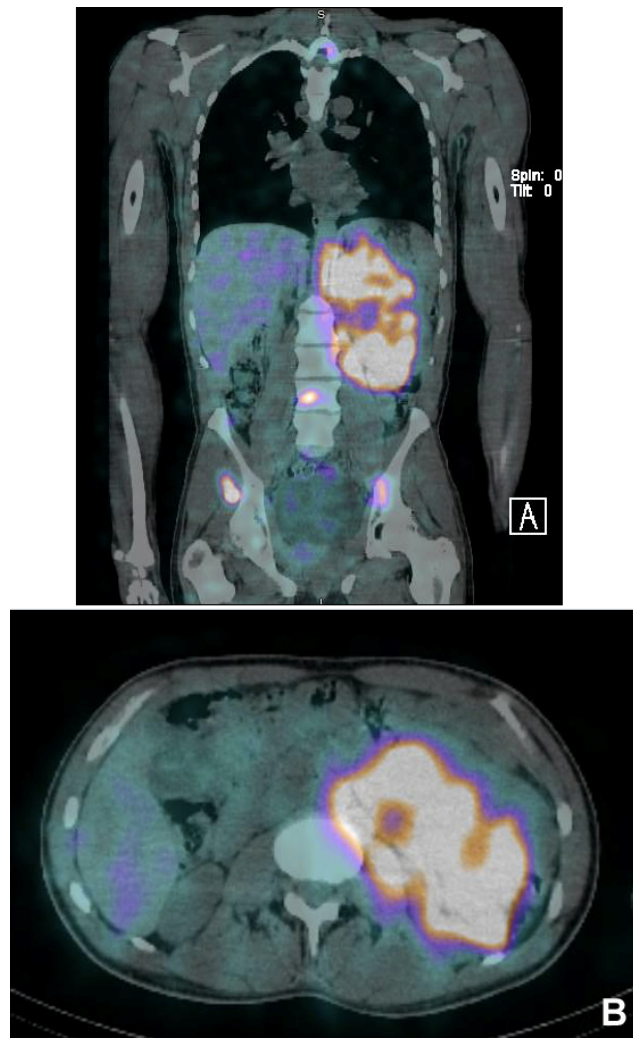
CT scan of the abdomen demonstrating (a) the small liver metastasis and superior portion of large adrenal mass and (b) the large adrenal mass with central necrosis at its largest point
